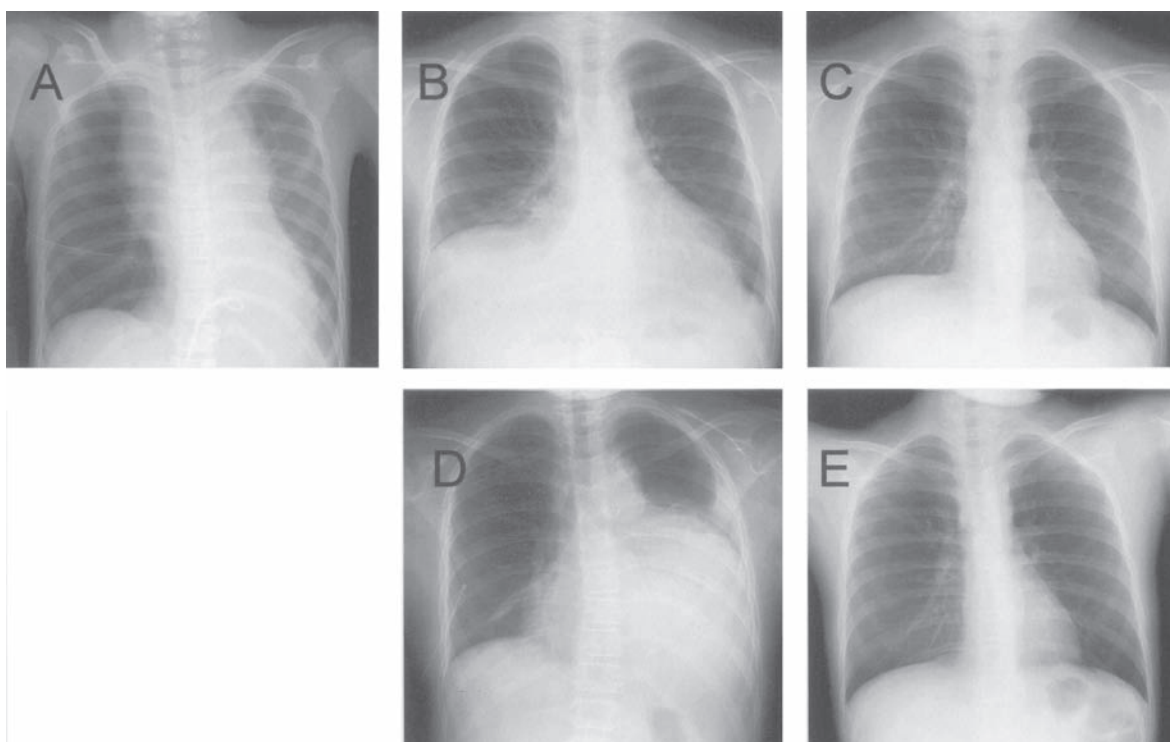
The chest X-ray findings at initial presentation (a), just before stem cell transplantation (SCT) (b), 49 days after SCT (c), at relapse (d), and 48 days after relapse (e).
